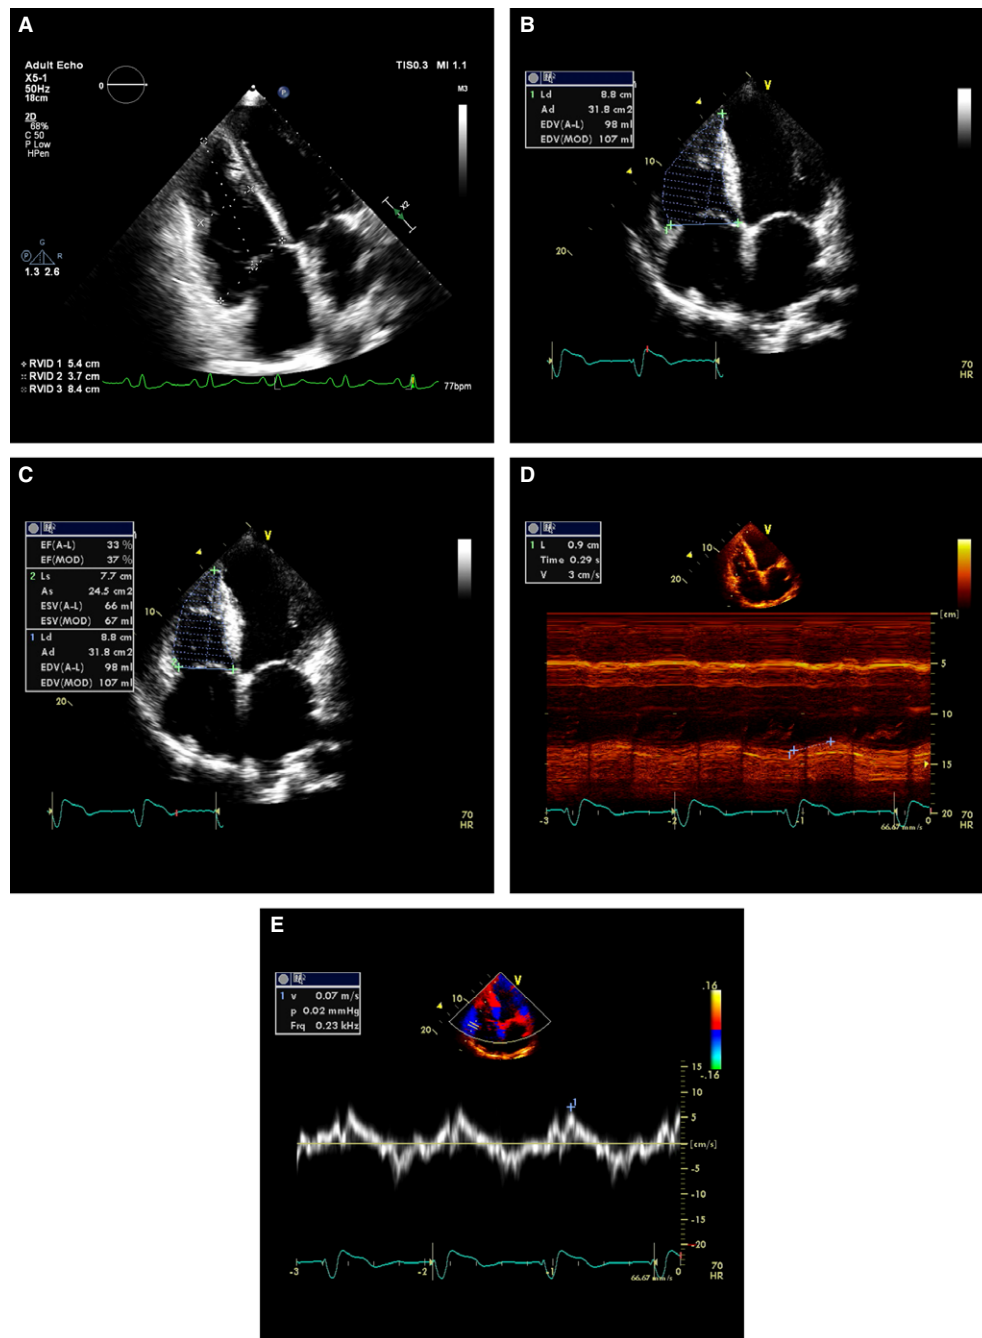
Morphological and functional measurements of the right ventricle. A. Right ventricular dimensions from the RV-focused view; RV area at end-diastole B. and end-systole C. used to calculate fractional area shortening; RV systolic longitudinal function measured from M-mode TAPSE D. and tissue Doppler RV S' E. RV = right ventricular.
